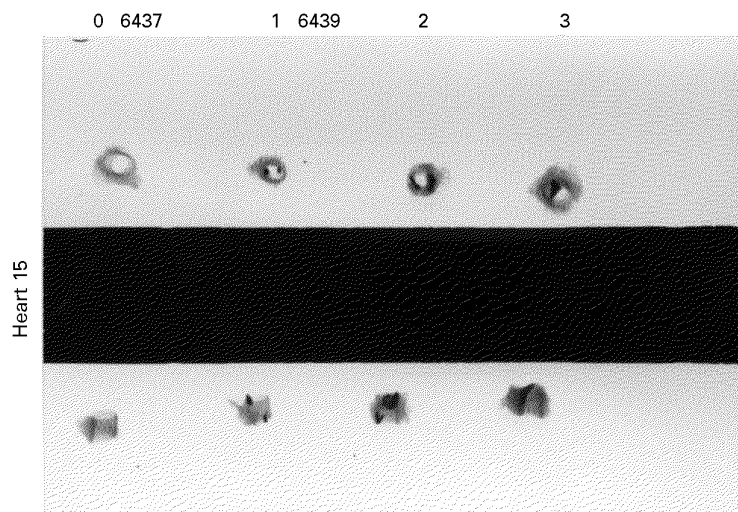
Identification and localisation of calcium with longitudinal and cross sectional radiographs of coronary arteries from heart 15: left anterior descending (6437; 0) and three sites from the right coronary artery (6439; 1, 2, 3).
